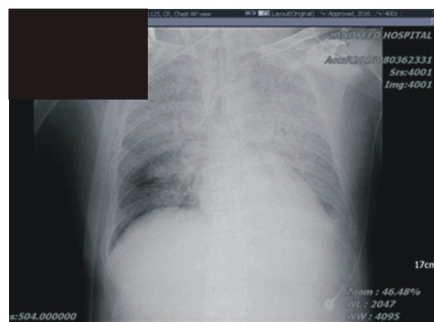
Chest X-ray presentation on VV ECMO Day 1
